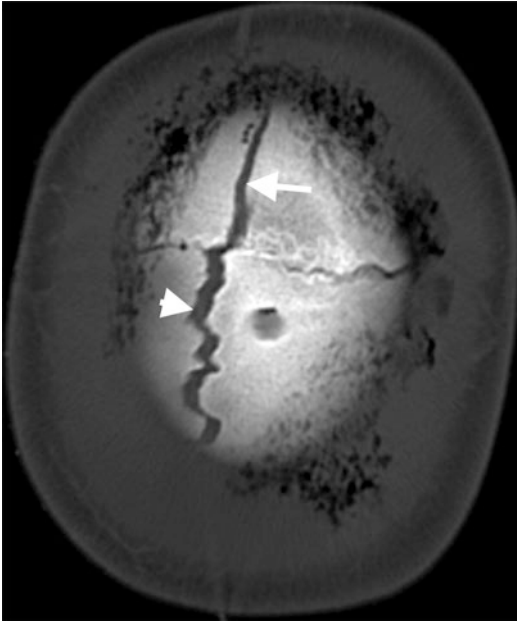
Cranial fracture with diastasis of neighboring suture. Axial CT image shows linear fracture (arrow) in the vertex that extends from the frontal bone and results in diastasis of the sagittal suture (arrowhead)
